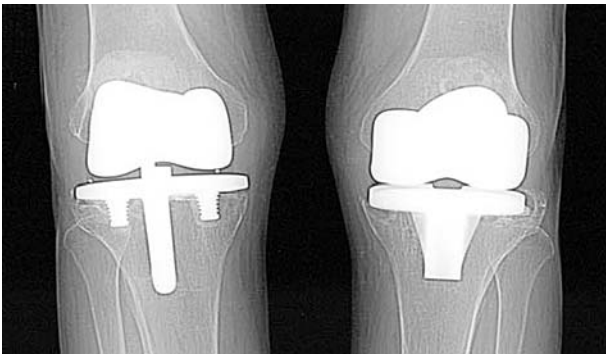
Radiograph of bilateral total knee prostheses with a Rotaglide mobile-bearing implant in the right knee and a NexGen CR fixed-bearing implant in the left knee.
